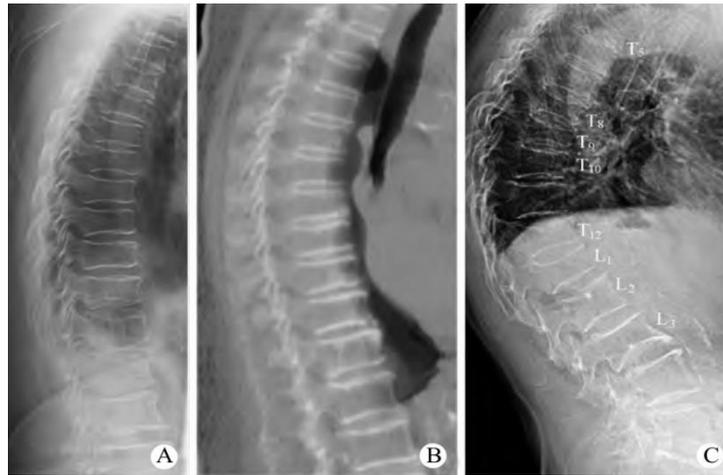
Chest imaging of elderly women. A. Lateral plain film shows concave upper and lower endplates of T7, T8, and T9 vertebrae. The projection of the endplate ring is a clear elliptical shape (arrow), indicating the rotation of the vertebrae relative to the X-ray beam. The anterior height of the T7-9 vertebral bodies remains unchanged.<sup>[16]</sup> B. Reconstruct sagittal CT images; C. Coronal CT images; Display slight scoliosis of T6-9 vertebrae (facing to the right), and no significant deformation of T7-9 vertebrae.
